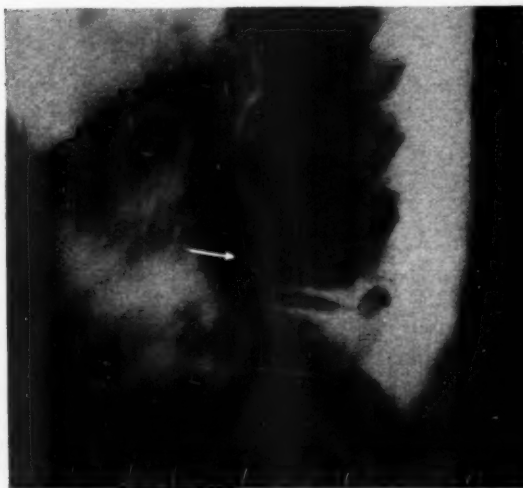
Case 1. X-ray nine months after Figure 5. Bony restoration of trabeculae.
